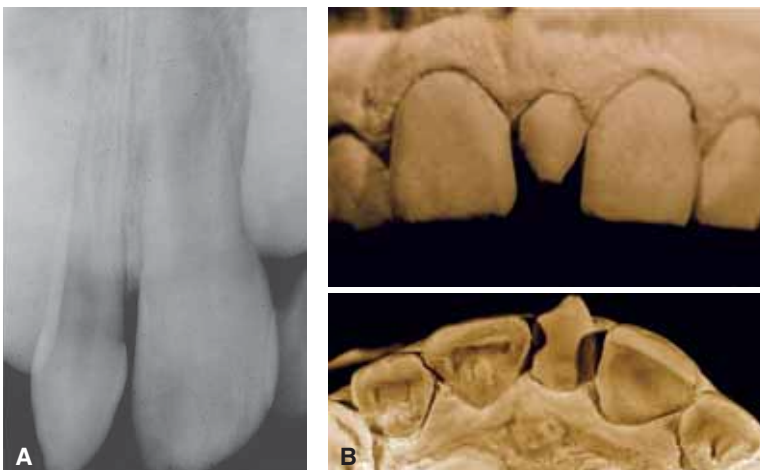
Supernumerary mesiodens. A. Radiograph showing a mesiodens next to the fully erupted permanent maxillary central incisor. B. Fully erupted mesiodens (facial and incisal views) that has a peg shape.
